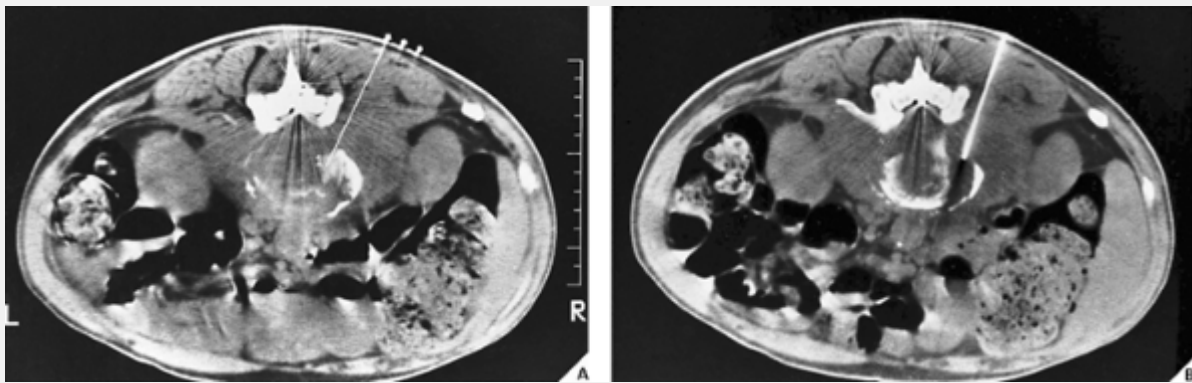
CT-guided aspiration biopsy. Aspiration biopsy of an infected intervertebral disk is performed under CT guidance. (A) Measurement is obtained from the skin surface to the area of interest (intervertebral disk). (B) The needle is advanced under CT guidance and placed at the site of the partially destroyed disk.
